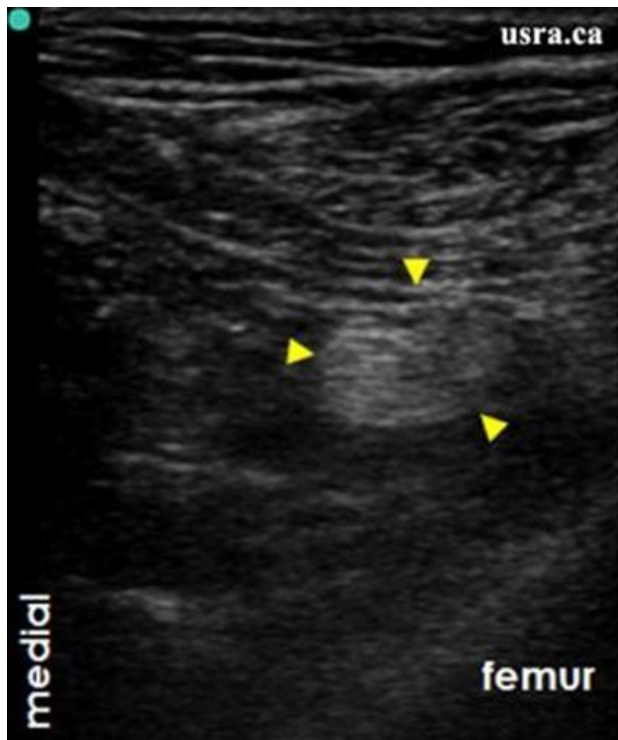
Ultrasonogram showing the sciatic nerve (arrowheads) in the popliteal fossa before its bifurcation.
